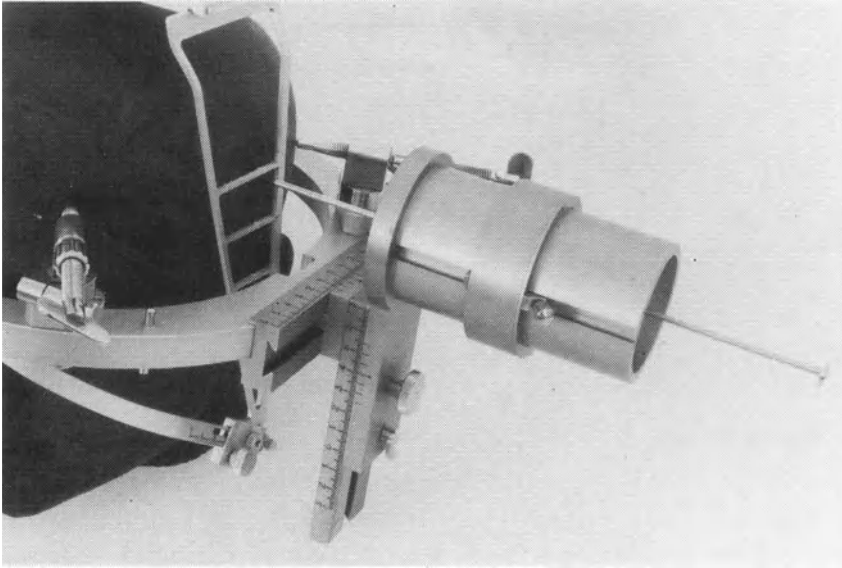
The Y and Z coordinates from the CT study are added to the Y and Z readings of the frame, respectively, and the cylinder component is positioned accordingly. A similar procedure is performed on the other side of the frame. When the cylinder positions of the two sides have been aligned in relation to the lateral site of the target, the target will lie at the common cylinder axis.
